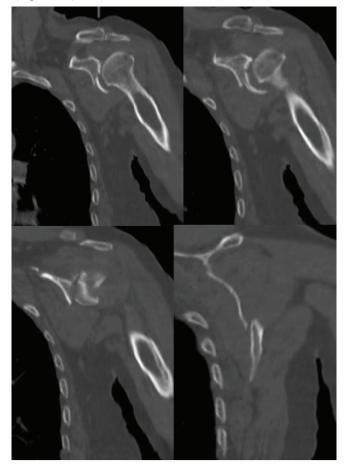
Joint CT coronal section: Displaced glenoid fracture.
